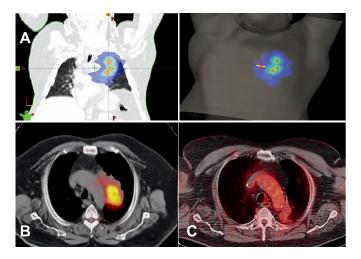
LRT for a stage IIIA lung tumor as upfront boost (61): 18 Gy to the vertices, 3 Gy to the periphery of the PTV. Panel A (top row): Dose distribution. Panel B: Tumor prior to treatment. Panel C: Follow-up PET-CT 15 months after LRT followed by 2 Gy \times 29 fractions of VMAT.
